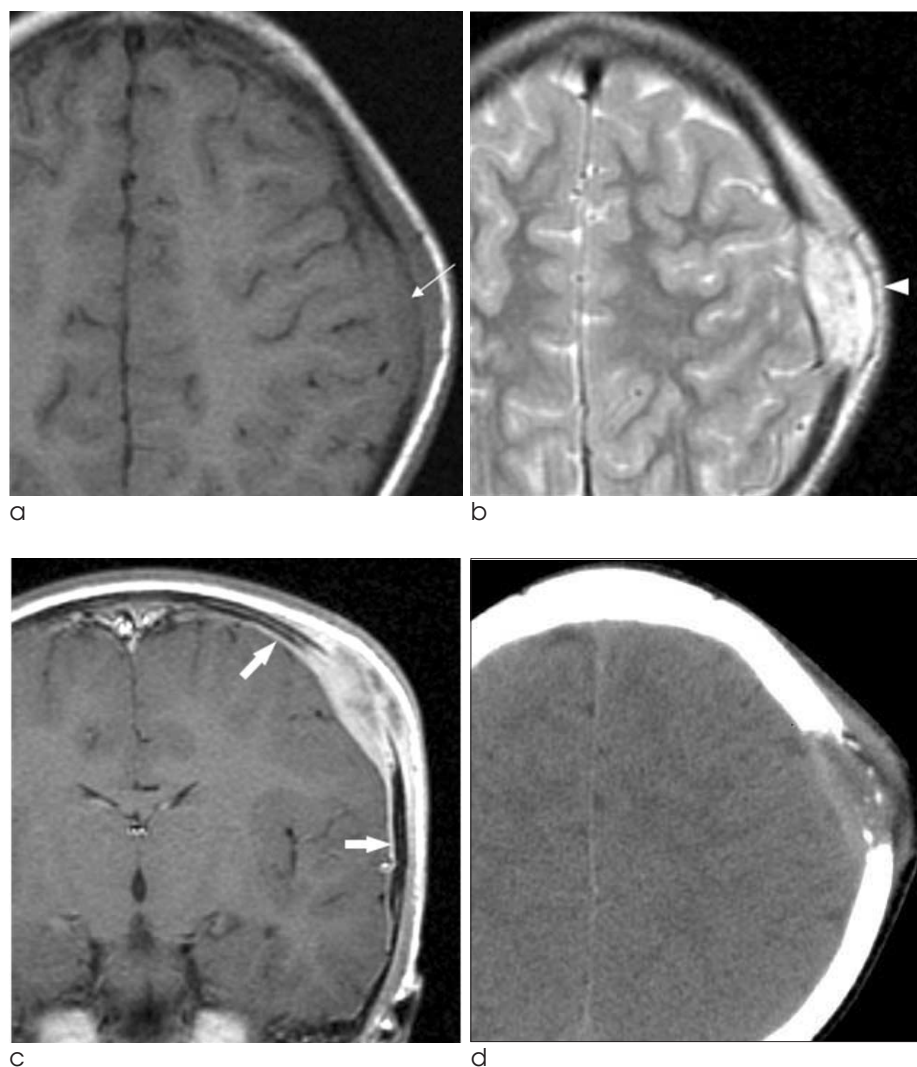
a-d. A 29-year-old woman with LCH. Axial T1-weighted (a) and T2-weighted images (b) show iso (arrow) and high signal intensity (arrow head) of the mass. MR images also show osteolysis of the skull and extension of the mass to the scalp. Coronal contrast-enhanced T1-weighted image (c) shows strong enhancement of the mass. Adjacent dural thickening and enhancement (arrows) is clearly seen on this image. Axial contrast-enhanced CT scan (d) shows well-enhancing osteolytic mass in left frontal bone. Extra-cranial extension of the soft tissue mass is clearly seen.
